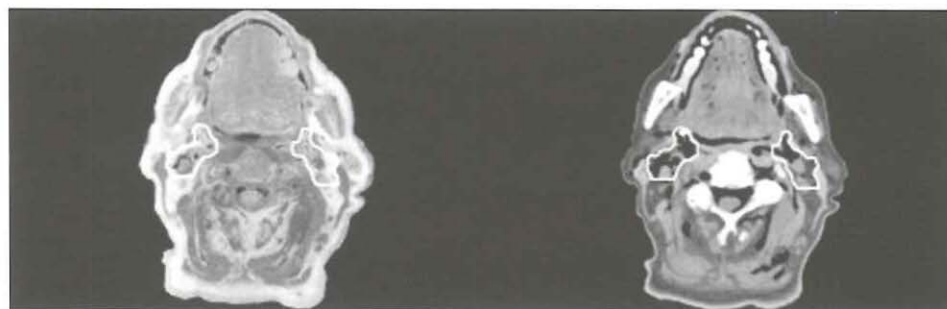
Region 2 (high-jugular lymph nodes): The borders of this region are outlined on a transversal anatomy slice (left panel) and the matched CT slice (right panel), in between the cranial (cranial CT slice through vertebra C-1) and caudal (hyoid bone) borders. The borders are discussed in the text and in Table 1.
